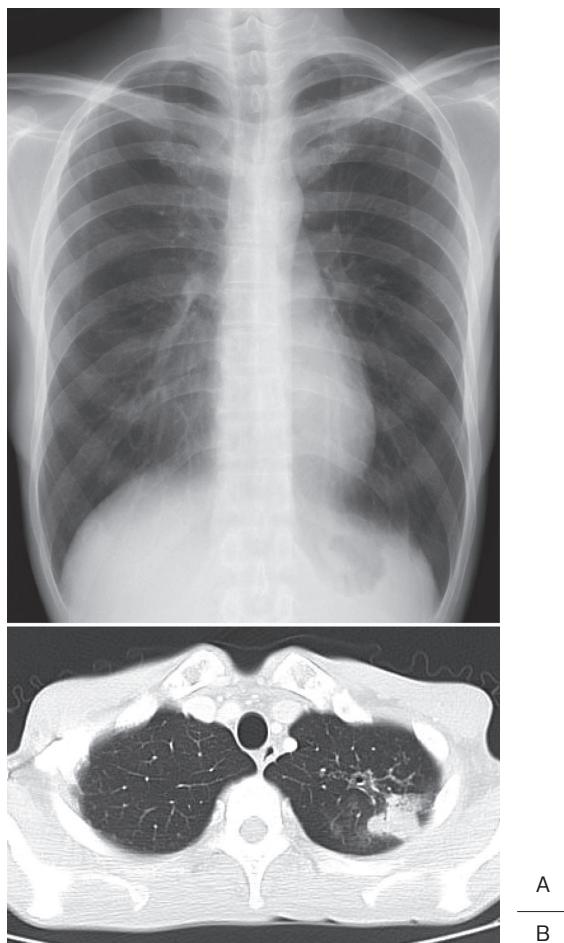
Radiological findings. A, Chest X-ray showed an infiltrative shadow in the left upper lung field. B, Chest CT revealed a 24-mm nodular shadow in the left S¹⁺² and disseminated shadows around it.
